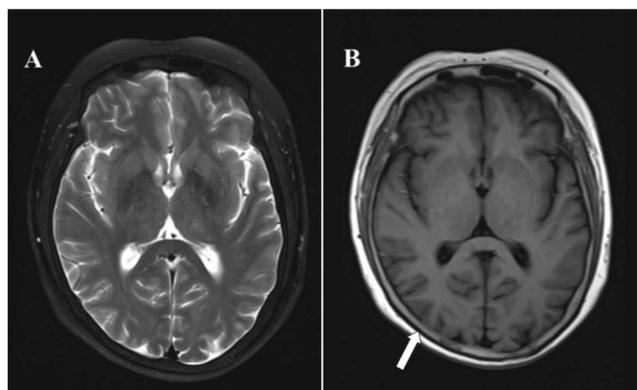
Axial MRI of the patient. a T2-weighted MRI (T2WI) showing no abnormal signal. b T1-weighted MRI (T1WI) showing thickened meninges
